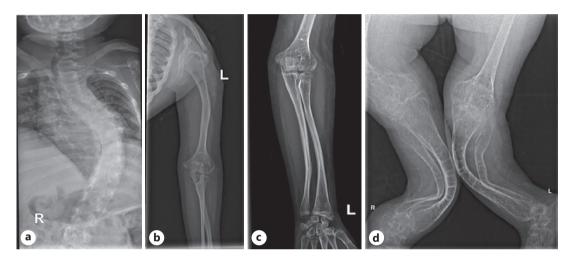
X-ray findings of our patient. a Scoliosis on the vertebrae. b, c Bowing of the arm bones. d Bowing of the leg bones.
